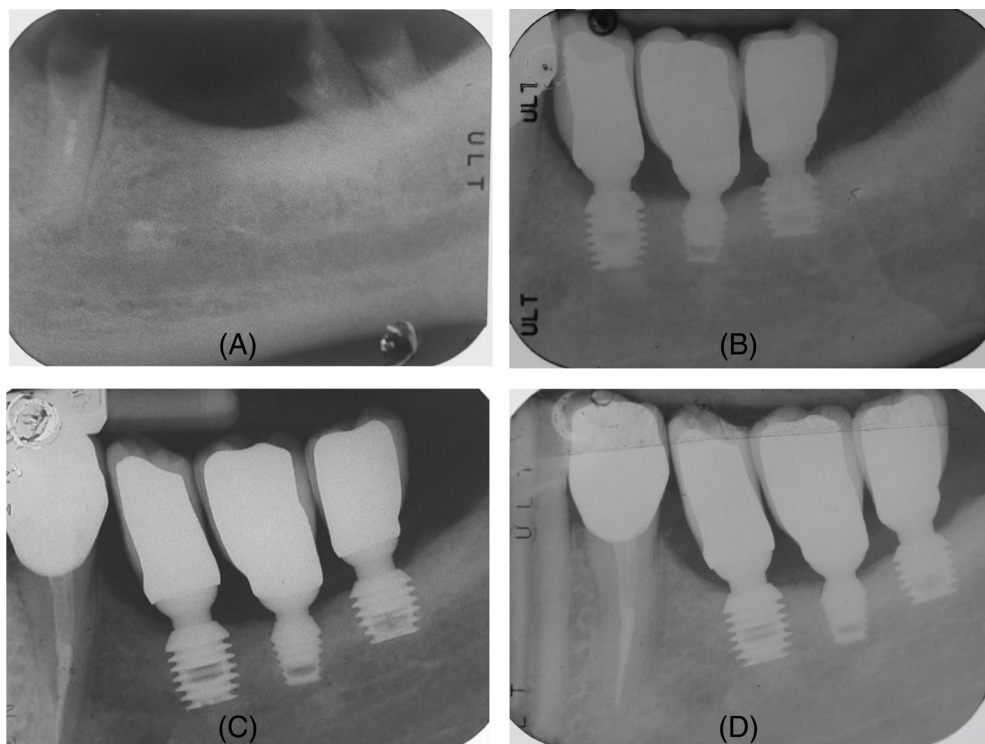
Single implants placed in 3.4, 3.5, and 3.6 sites (5 × 6 mm, 4 × 5 mm, 5 × 5 mm): (A) Preoperative radiograph before implants placement; (B) radiograph obtained at time of loading; (C) radiograph obtained at 3-year follow-up; (D) radiograph obtained at 5-year follow-up
